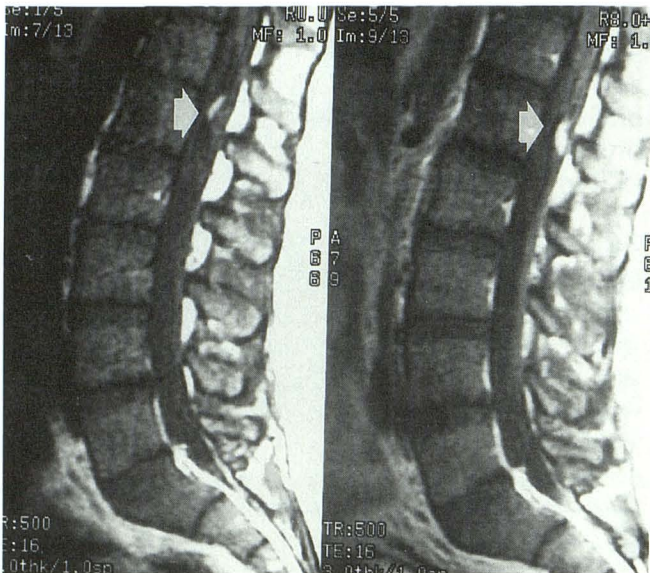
Sagittal spin-echo T1-weighted images (500/16/1.0 [repetition time/echo time/excitations]; 256 × 192 matrix size; 3-mm section thickness; 1-mm interspacing) obtained before (left image) and after (right image) administration of gadopentetate dimeglumine. There is a small focus of abnormal increased signal (left image, *white arrow*) inferior to the conus medullaris, at the L-1 level. This lesion demonstrates homogeneous enhancement (right image, *white arrow*).
